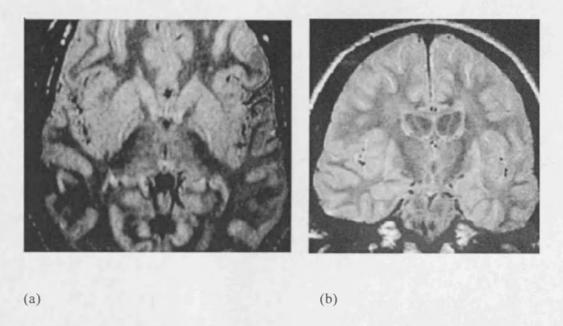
Proton density MRI showing (a) pallidal atrophy in a patient with severe secondary generalised dystonia due to perinatal septic-anoxic encephalopathy. (b) Striatal atrophy particularly affecting caudate in another patient with severe secondary generalised dystonia.
